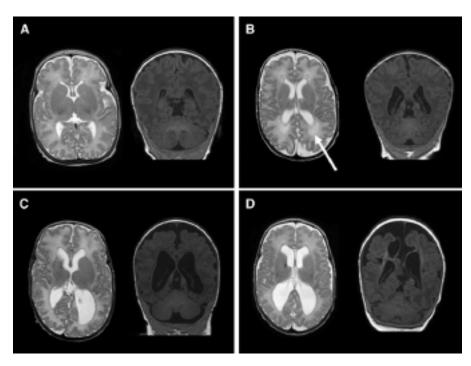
MRI brains scans of WMA at term age. A normal MRI scan, B mild WMA (arrow refer to DEHSI), C Moderate WMA, D severe WMA¹⁴ Reprinted from The Journal of pediatrics 2012; 160: 559-66. Neonatal magnetic resonance imaging and outcome at age 30 months in extremely preterm infants. Copyright (2022), with permission from Elsevier
